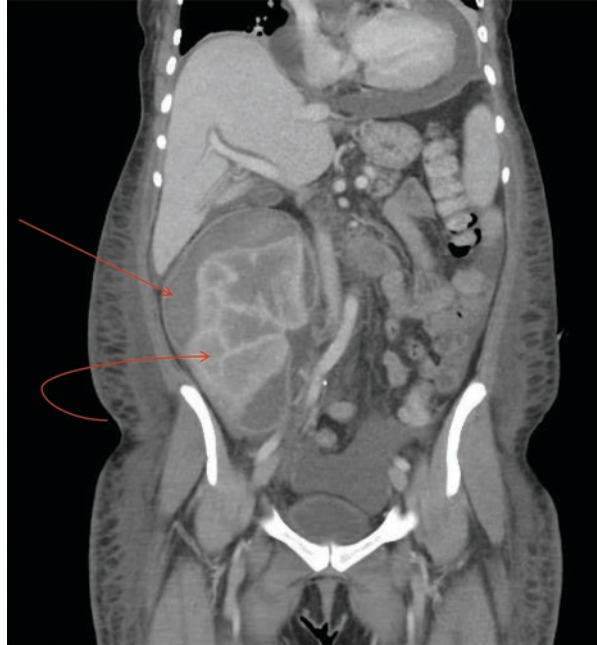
CT abdomen and pelvis without contrast, coronal view, showing perinephric hematoma (arrow) medial to the transplanted kidney after anastomotic breakdown
